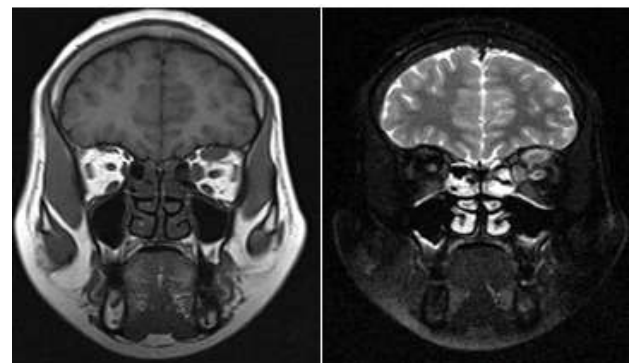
MRI orbit shows bulky superior rectus and medial rectus muscle at the belly as well as insertion site consistent with orbital pseudotumour.
